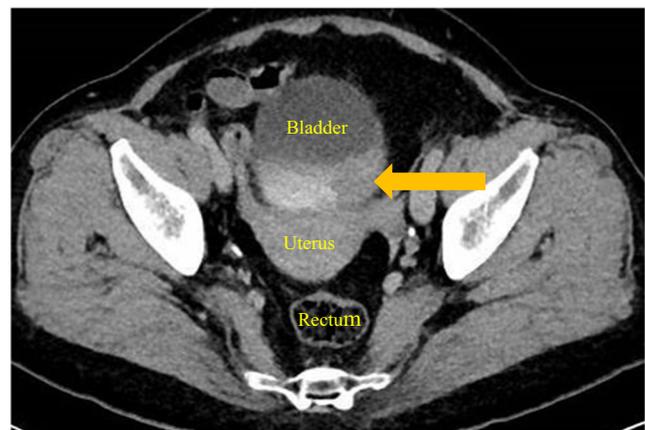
Computed tomography (CT) urogram showing an irregular nodular soft-tissue mass measuring 3.4 × 2.3 × 1.2 cm in the posterior lateral wall of the urinary bladder, in keeping with the mass noted on cystoscopy
